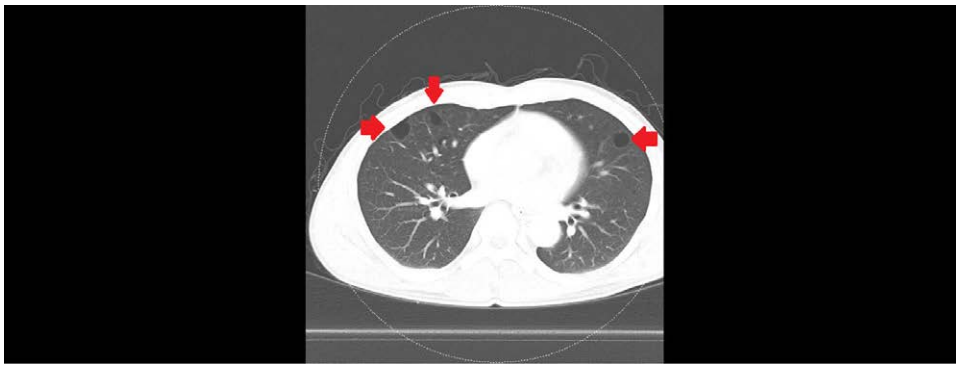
Chest computed tomography reveals bilateral cysts in various shapes and sizes, located predominantly within the lower lobes.
